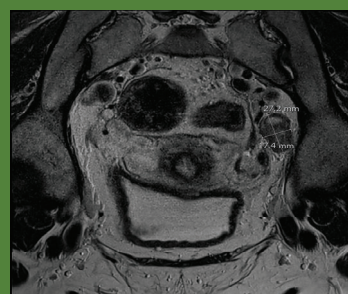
Left external iliac/ obturator lymph node (coronal view, MRI)
